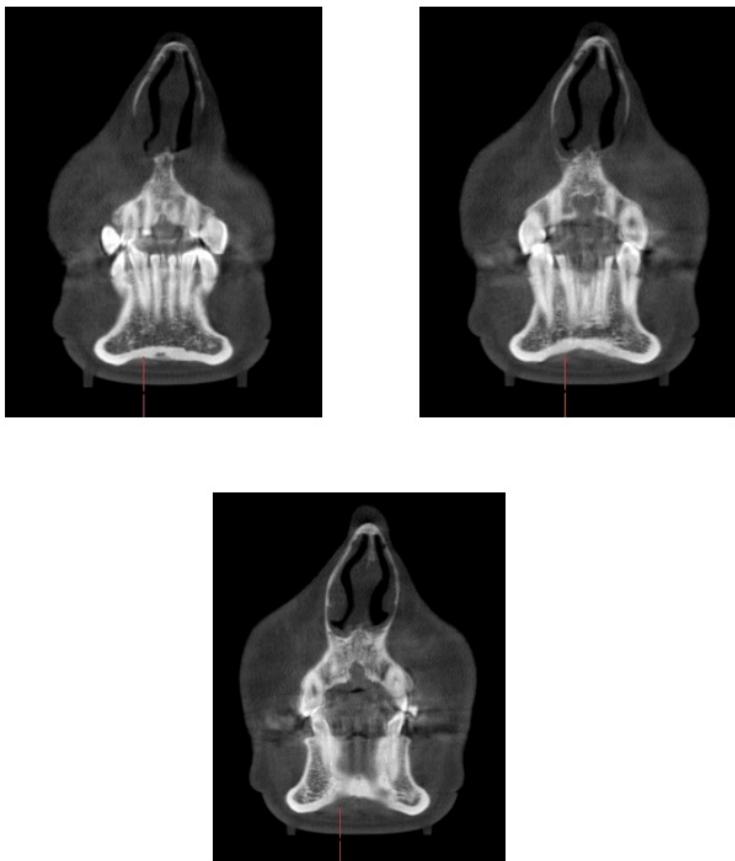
Coronal CBCT images show a nasopalatine duct cyst.
